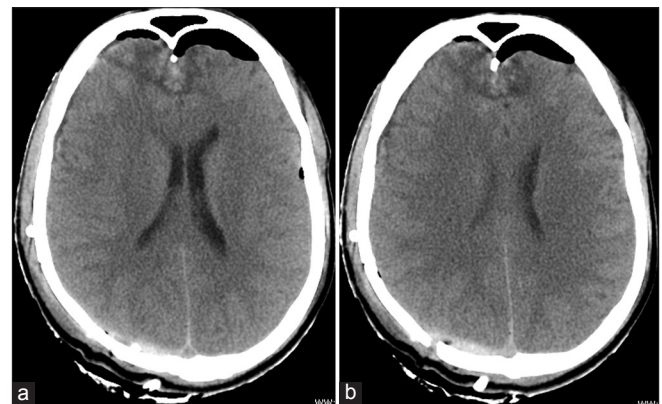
Follow-up CT scan showing complete evacuation of EDH and SDH
